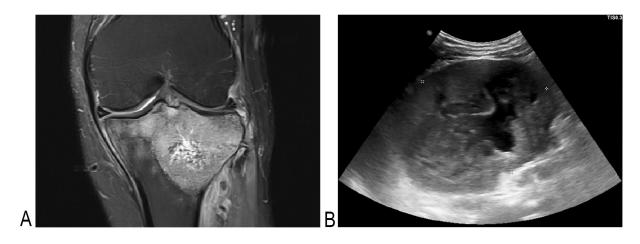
Imaging (A) MRI shows hyperintense lytic lesion with wide zone of transition centered in the epimetaphysis of the left proximal tibia, with surrounding soft tissue edema; (B) Ultrasonogram shows iso- to hypoechoic mass lesion in the upper pole of the left kidney with dilated pelvicalyceal system.
